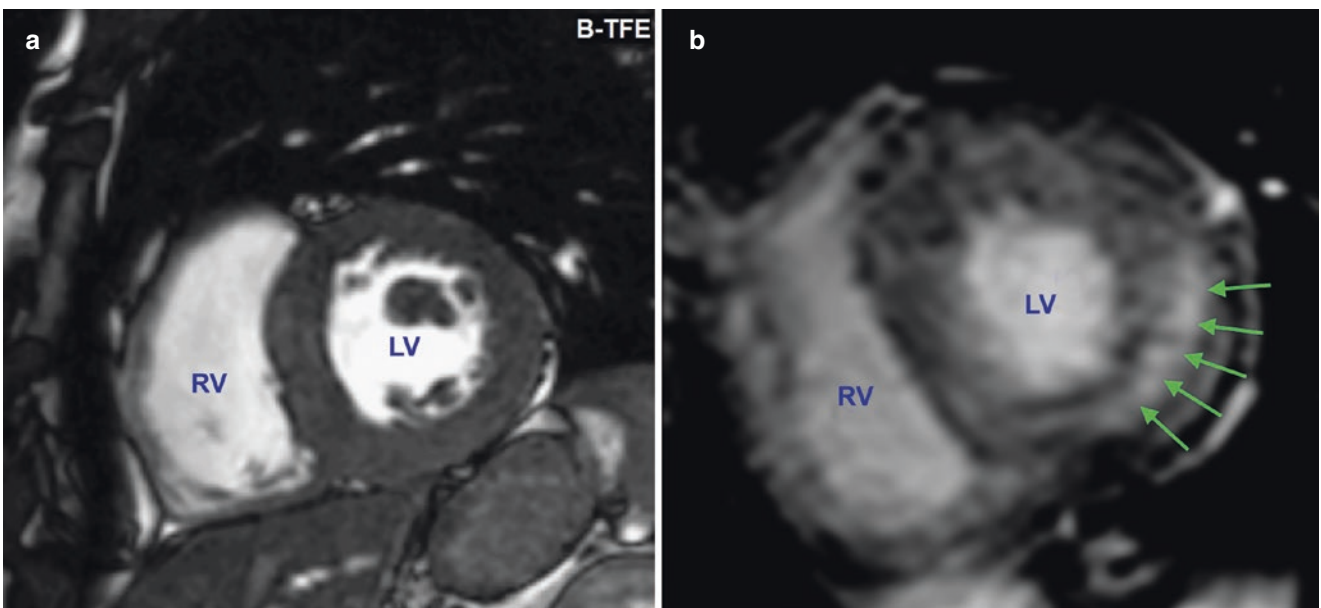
Cardiac MRI findings in AFD showing diffuse left ventricular hypertrophy (left panel) and replacement fibrosis demonstrated by late gadolinium enhancement (right panel—green arrows) distributed in a typical localization for AFD, affecting midwall layer of the posterolateral basal left ventricular segments
